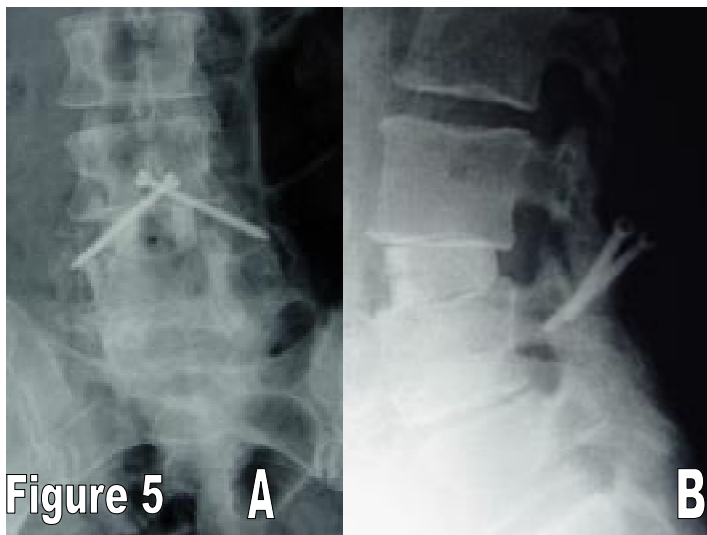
(A and B): A: AP x-ray of circumferential fusion L3-4 secondary to transitional syndrome above a solid L4-Sacrum fusion. Femoral ring allograft is anterior and translaminar facet screws posterior. B: Lateral x-ray of the ALIF and translaminar facet screws L3-4.
